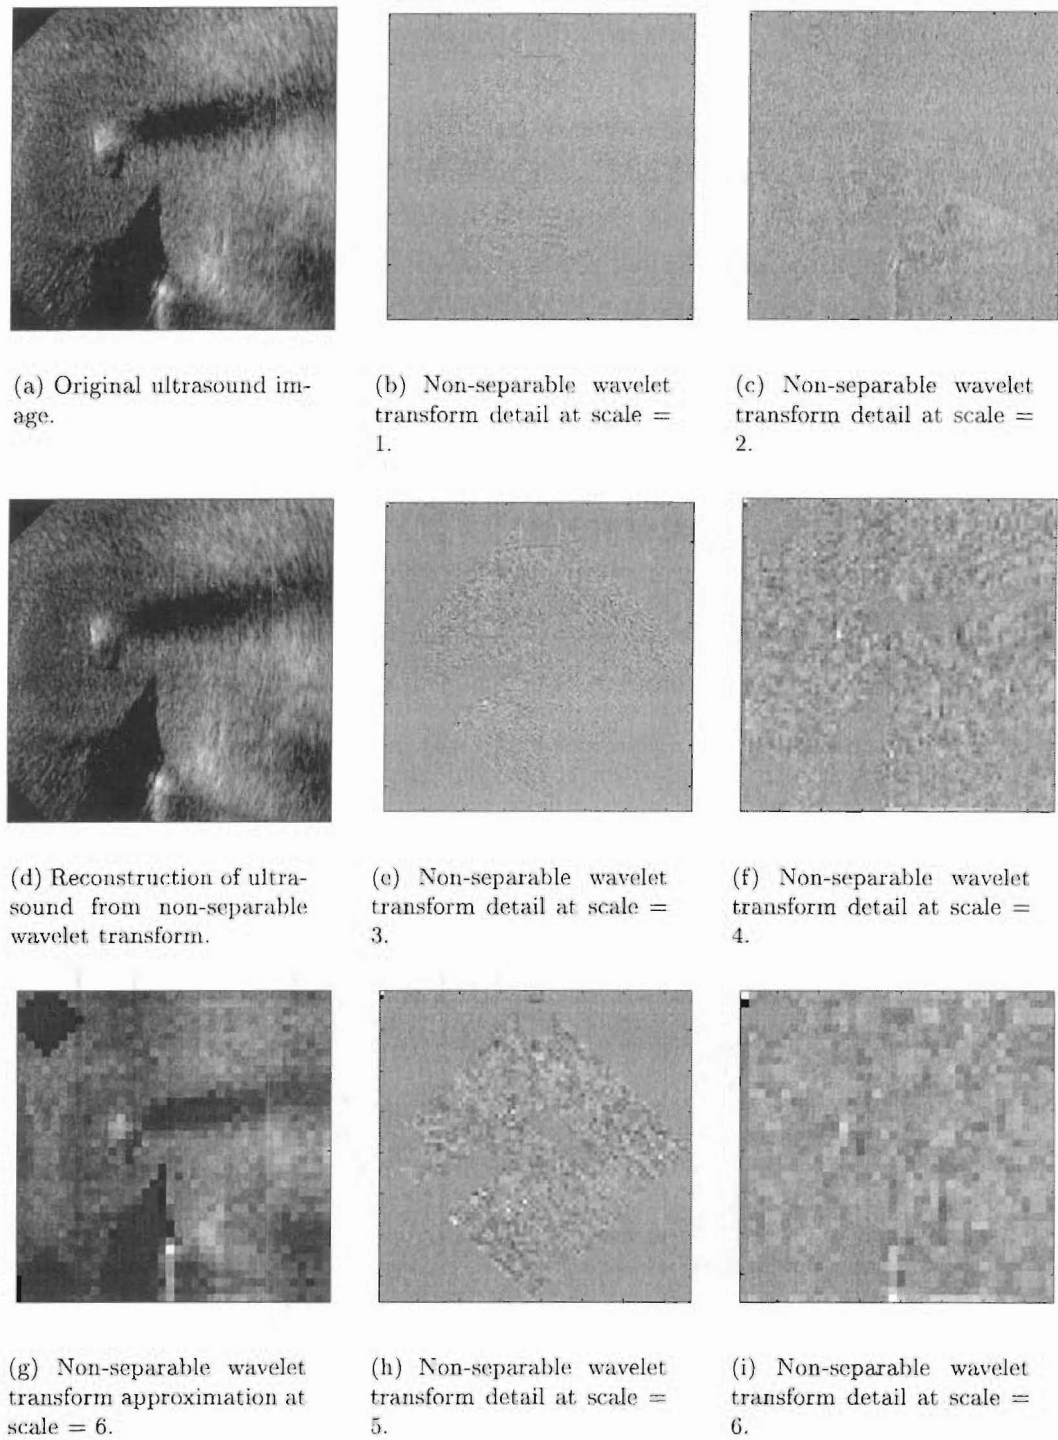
Non-separable wavelet transform of ultrasound. Left-hand column: (a) Original, (d) Reconstruction, (g) Approximation at scale, $j = 6$. Centre column: (b,e,h) Details for odd scales, $j = [1, 3, 5]$. Right-hand column: (c,f,i) Details for even scales, $j = [2, 4, 6]$.
